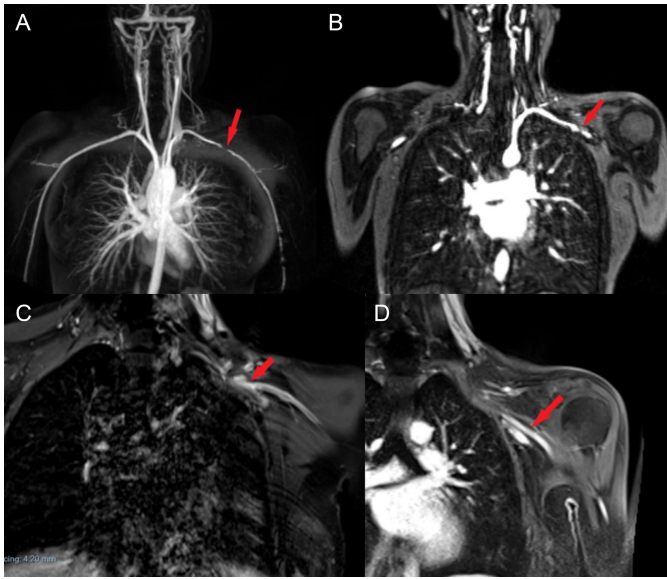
(A) Coronal section, maximum intensity projection reconstruction of an early arterial phase MRA shows a pseudostenosis in the left subclavian artery in a healthy subject (red arrow). (B) In early arterial-phase MRA, severe stenosis was observed in the middle section of the left subclavian artery (red arrow). (C) In the delayed-phase magnetic resonance imaging-fat suppressed T1WI, left subclavian vein and subclavian artery calibrations were normal. There was no pathological appearance that caused the compression of the subclavian artery or the subclavian vein. (D) A delayed-phase magnetic resonance imaging-dedicated subclavian scan shows that the suspected pseudostenosis seen during the early arterial phase magnetic resonance imaging is no longer visualized when imaging the same subject during the venous phase magnetic resonance imaging (red arrow).
